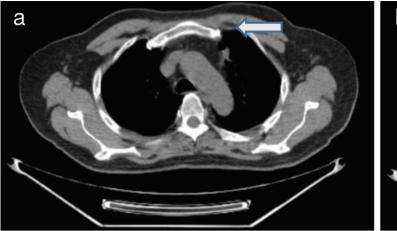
(a) Baseline radiological evaluation of the primary tumor. Computed tomography (CT) revealed a 2.9x2.2 cm mass in the left upper lung. b) Baseline radiological evaluation of right isolated adrenal metastasis (11x8x5 cm) (PET/CT).
